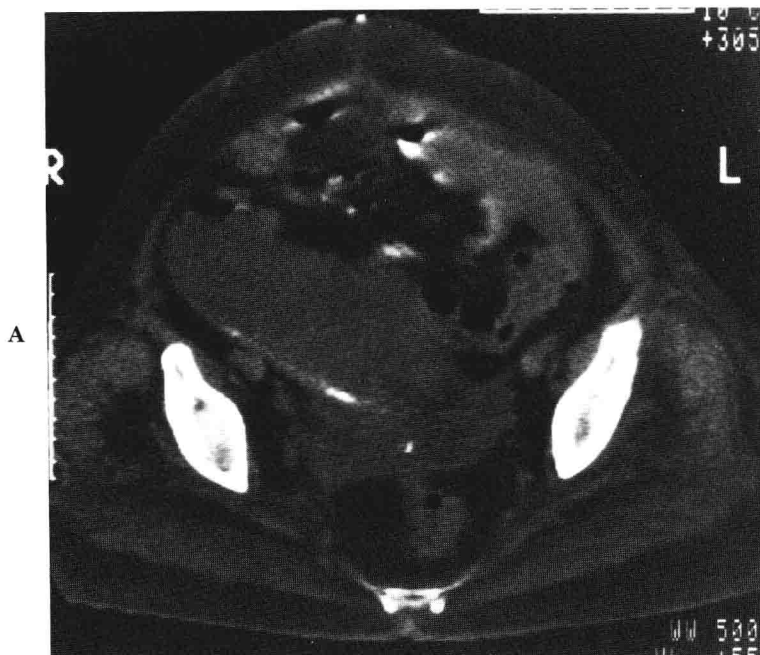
Unsuspected ileal perforation with pelvic abscess. A, CT scans of the midpelvis in a patient who developed a fever 5 days following aortic aneurysm surgery. There is an amorphous fluid collection. A small area of increased density represents extravasated oral contrast.
